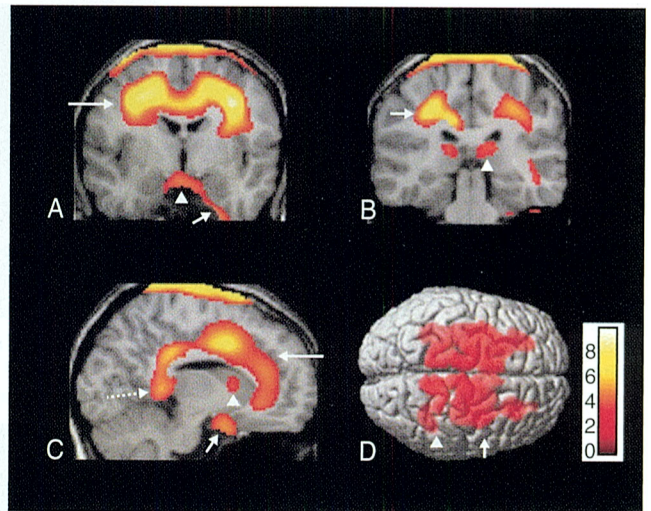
Functional brain changes in narcolepsy (technetium ^{99m}Tc ethyl cysteinate dimer single-photon emission computed tomography). Brain mapping of the regions where cerebral perfusion is decreased in narcoleptic patients compared to normal subjects. Results are overlaid on T1-weighted magnetic resonance imaging and are significant at false discovery rate (FDR)-corrected $P < .05$. A, Significant hypoperfusion was observed in bilateral anterior hypothalami (arrowhead) and in the right parahippocampal gyrus (short arrow). Bilateral cingulate gyri and white matter in bilateral middle frontal gyri (long arrow) showed decreased cerebral perfusion. B, Hypoperfusion was evident in bilateral posterior thalami (arrowhead) and in the white matter of the bilateral post-central and supramarginal gyri (short arrow). C, In the sagittal view of the right hemisphere, significant hypoperfusion was observed in the caudate nucleus (arrowhead), in the subcallosal gyrus (short arrow), the cingulate gyrus extending along the corpus callosum (long arrow), and in the parahippocampal gyrus (dotted arrow). D, Three-dimensional rendering showing decreased cerebral perfusion in bilateral paracentral areas (arrowhead) and superior/middle frontal gyri (short arrow). The frontal lobe is on the right and the occipital lobe on the left. (Reprinted from Yeon Joo E, Hong SB, Tae WS, et al. Cerebral perfusion abnormality in narcolepsy with cataplexy. *Neuroimage.* 2005;28:410-416. Copyright 2005, with permission from Elsevier.)
